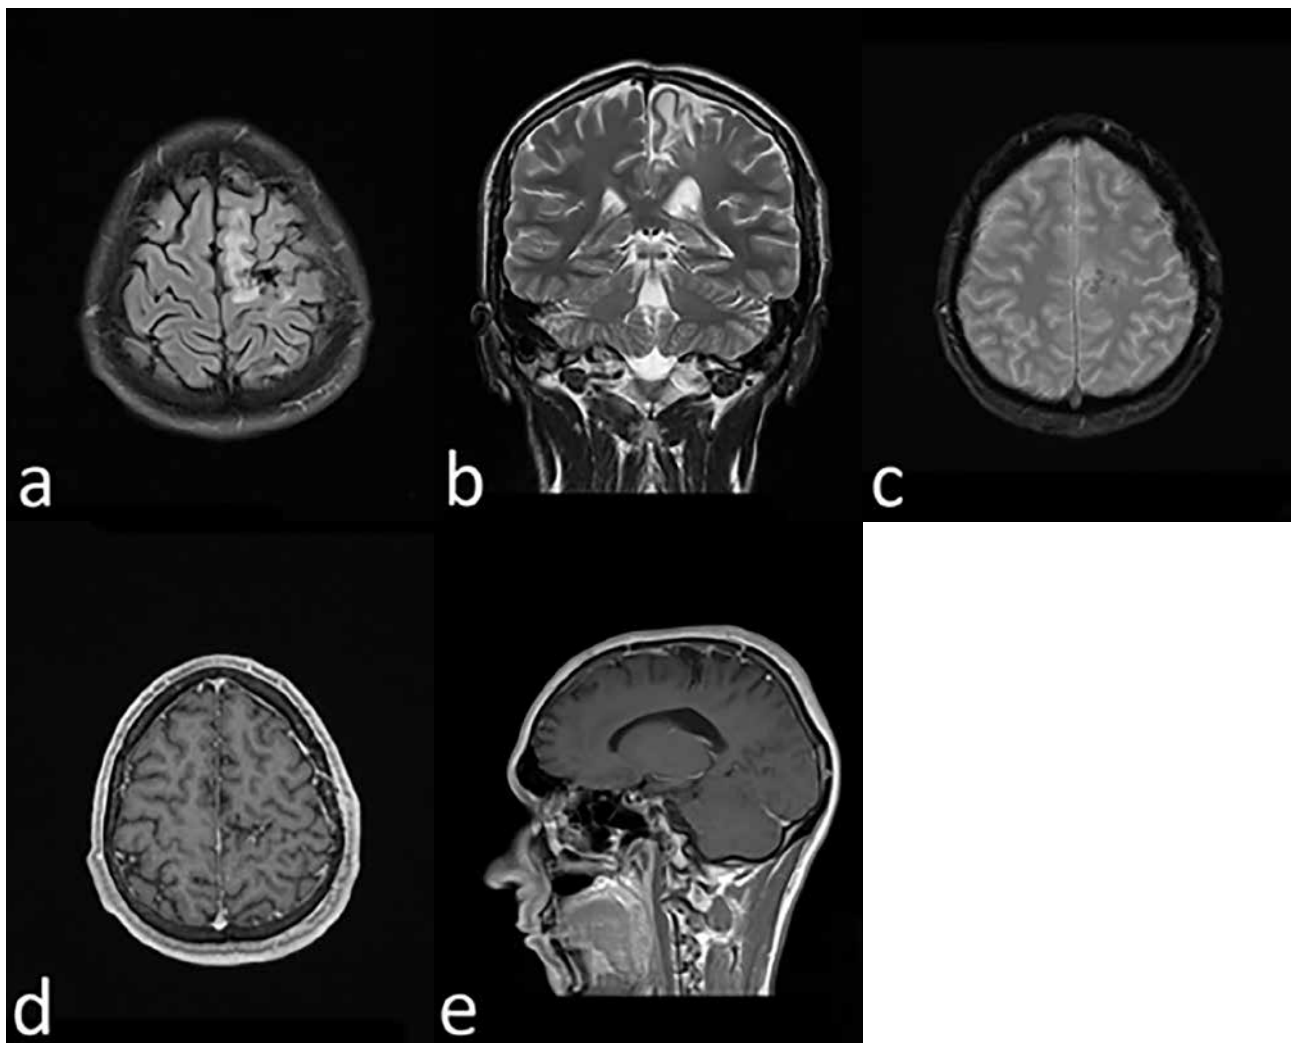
The postoperative control MRI (2016/2018). The postoperative cystic gliotic area at the left frontal lobe: T2W/FLAIR axial (a), T2W coronal (b), T2W/FLAIR/hemo axial (c), T1W post c/m, axial, sagittal (d, e).
